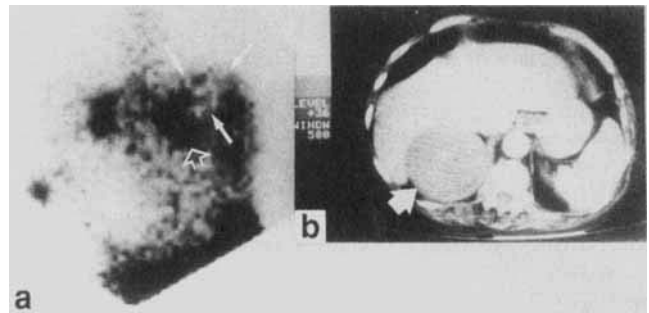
a Posterior ¹³¹I-6-β-iodomethyl-19-norcholesterol scintiscan depicts a normal left adrenal, a medially displaced right adrenal and a 'cold' area located laterally to the right adrenal (arrow). b Abdominal computed tomography scan identifies a 5 cm homogenous mass with a calcified rim in the right adrenal area (arrow)
